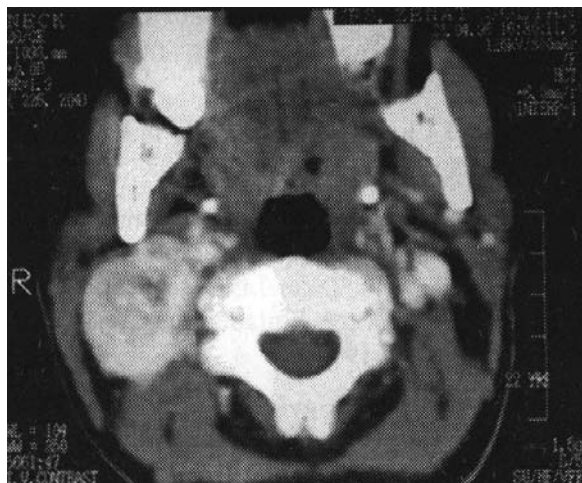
Axial contrast CT shows right carotid body tumor (from Som PM, Curtin HD. Parapharyngeal space. In: Head and Neck Imaging: 1996: 929).
